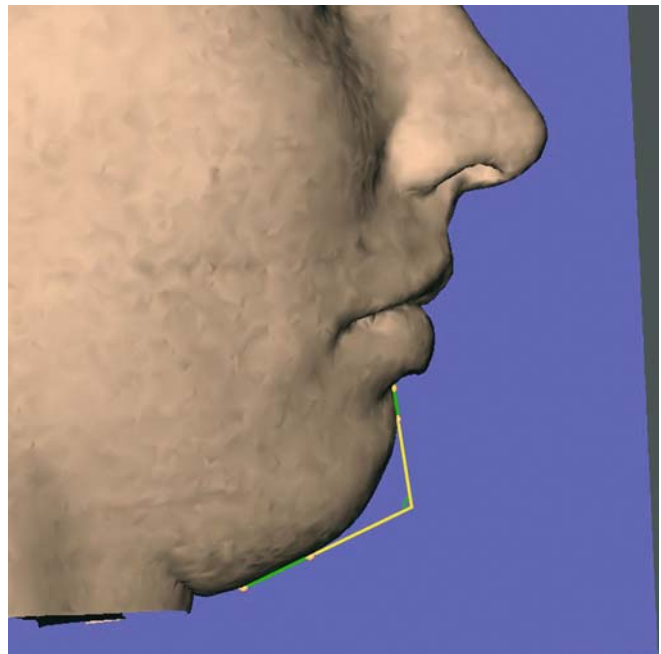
The mentocervical angle, $sl-pg / gn-gn'$, is a projected angular soft tissue measurement on the median (z) 3-D cephalometric reference plane. The landmark gnathion' (gn') localized on the midline tangent of the chin contour posterior to gnathion (gn), is used to determine the mentocervical angle (3-D CT, soft tissues, patient K.C.)
